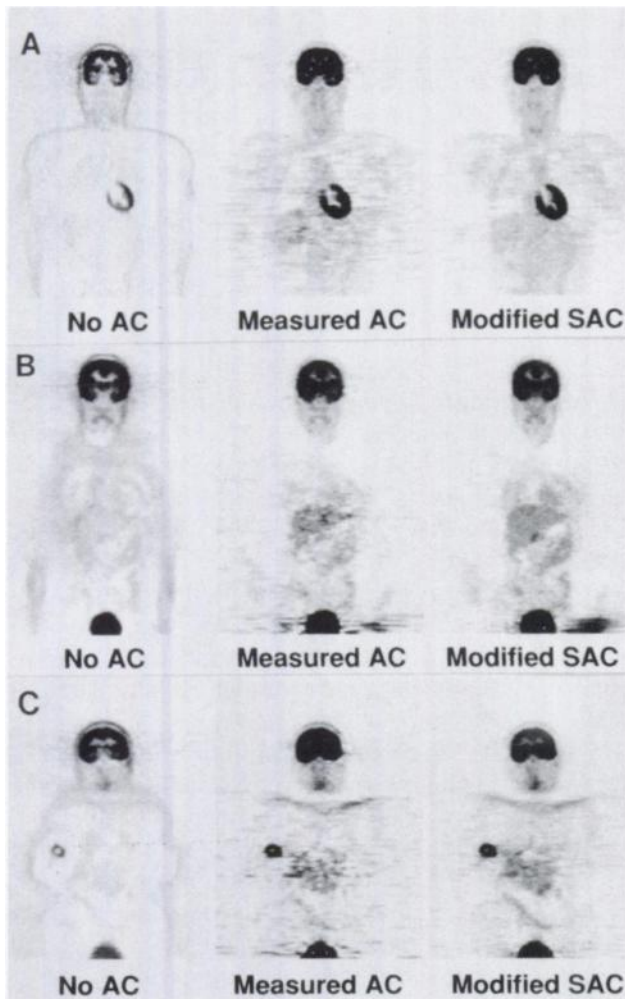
Coronal sections from whole body ^{18}F FDG PET studies performed on a male volunteer (A), a female patient with ovarian carcinoma (B) and a female patient with known breast carcinoma (C). Images were obtained using no attenuation correction (AC) (1st column), measured AC with sinogram smoothing (2nd column) and modified SAC (3rd column).
